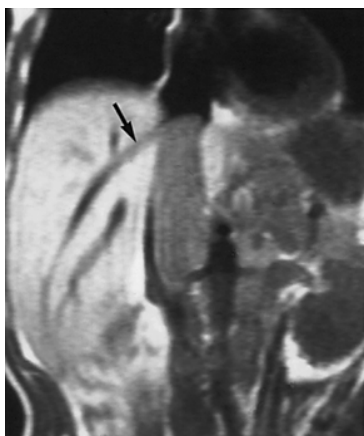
12. Inferior vena caval thrombus caused by large left-sided renal cell carcinoma. T₁ coronal magnetic resonance imaging demonstrates a large thrombus within the inferior vena cava with extension of the thrombus into the right hepatic vein (*arrow*).
